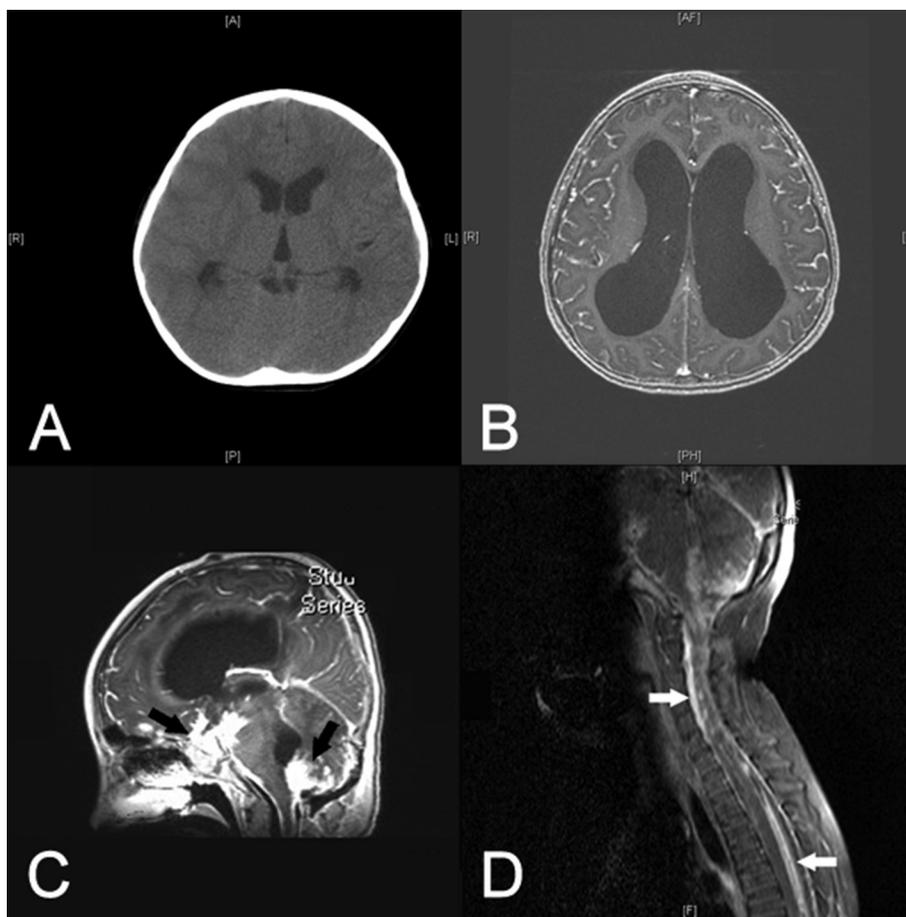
(A) Noncontrast brain computed tomography demonstrated mild ventriculomegaly. (B) Postcontrast T1-weighted axial brain MRI revealed dilated ventricles and diffuse leptomeningeal enhancement. (C) Postcontrast T1-weighted sagittal brain MRI showed dilated ventricles and diffuse pial–arachnoid enhancement in the basal cistern, the peripontomesencephalic cistern, and the cerebellum (arrow). (D) Postcontrast T1-weighted sagittal spinal MRI revealed diffuse intradural extramedullary lesions (arrow).
